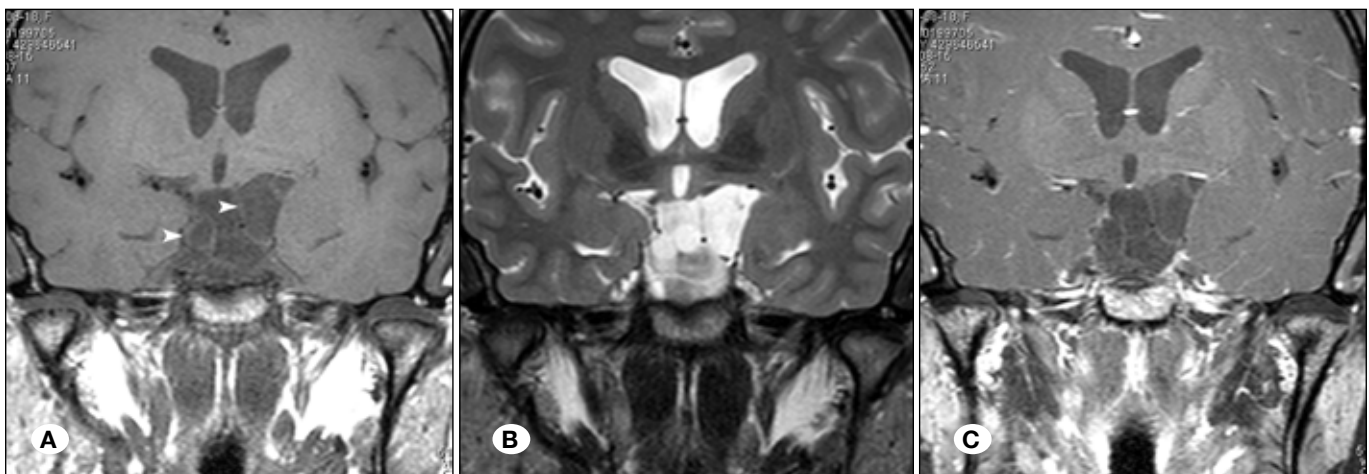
The coronal MR imaging of a 24-year-old female with subarachnoid NCC. A) T1WI, B) T2WI, C) contrast-enhanced T1WI. Multiple cystic lesions with long T1 and T2WI were found in the suprasellar cistern. The thin capsules of the lesions were demonstrated on T1WI with mild enhancement on contrast-enhanced T1WI. No visible scolex was found on imaging.
